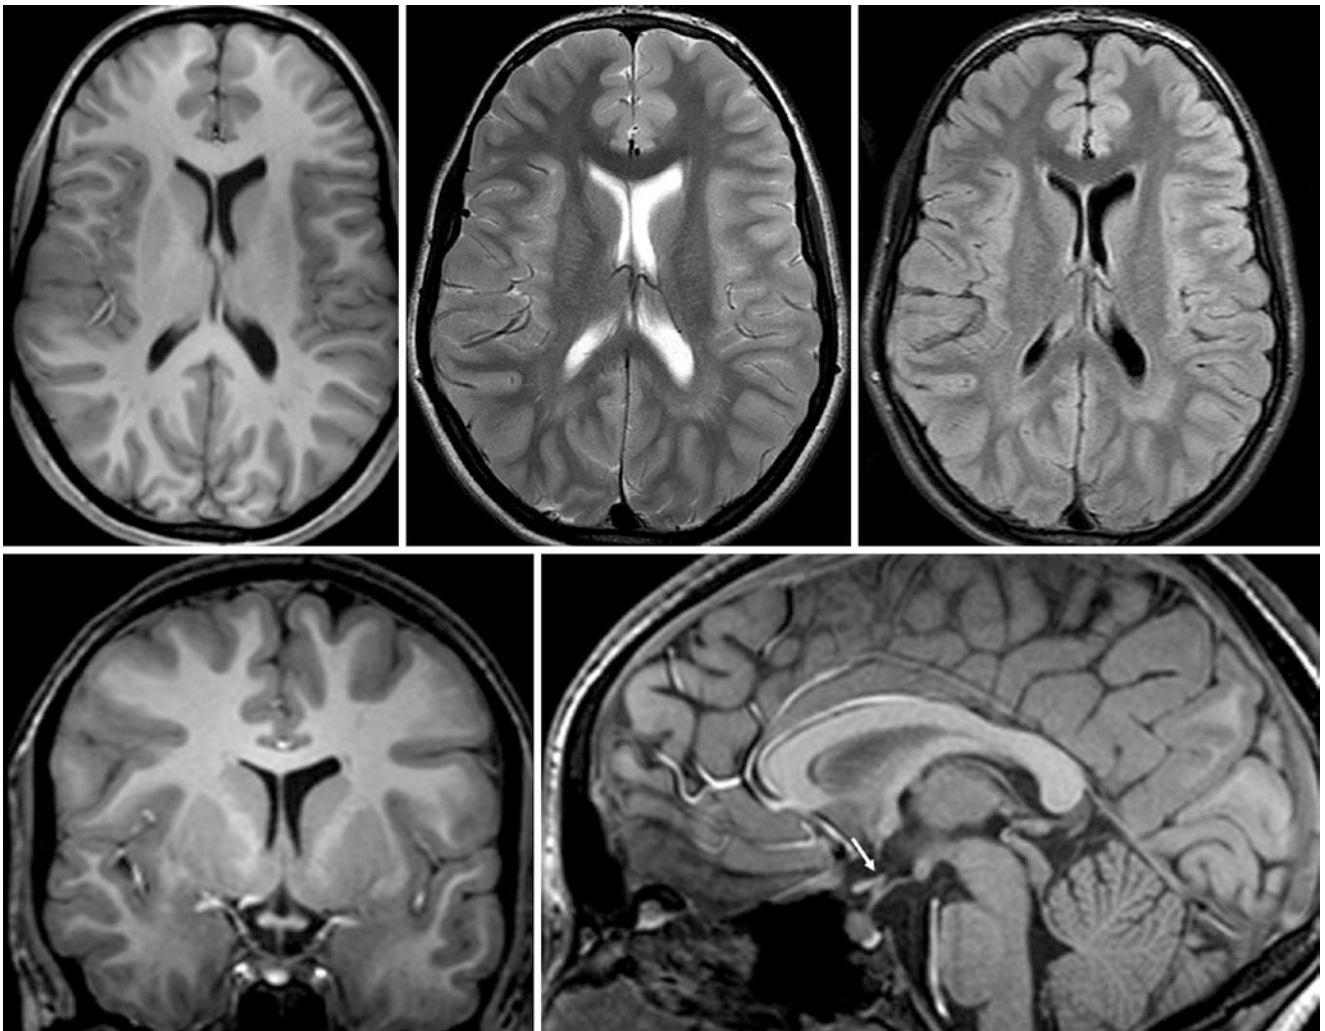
A 12-year-old patient whose 3T MRI included axial T1WI (*top left*), T2WI (*top middle*), FLAIR (*top right*), coronal T1WI (*bottom left*), and sagittal T1WI (*bottom right*). The MRI depicts a slightly
